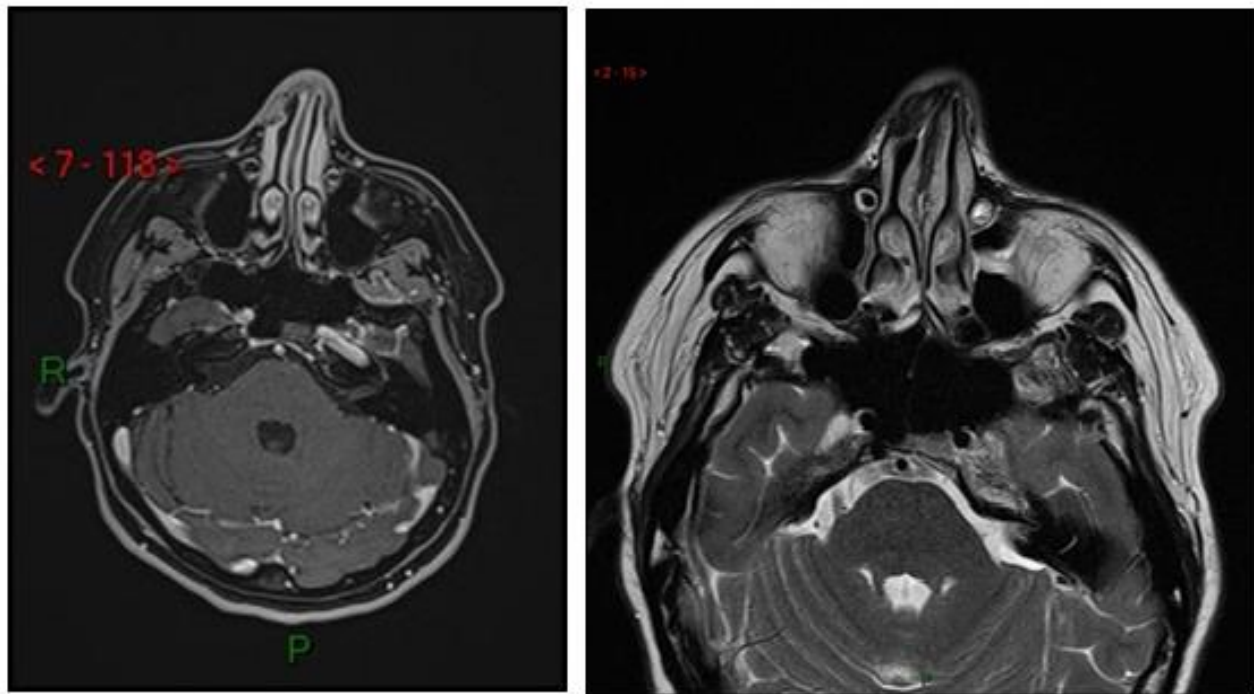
Post-operative MRI results at 3 months: no signs of recurrence. Left: enhanced fat sat sequence; right: T2 sequence
